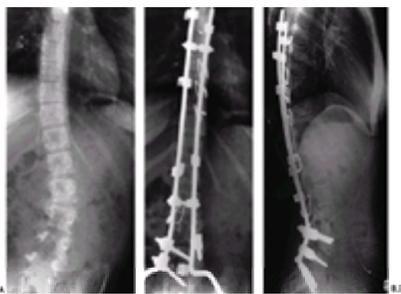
A 13-year-old girl has an L3-level paraplegia, but is not ambulatory. She is obese and has a progressive lumbar scoliosis and pelvic obliquity. A tethered spinal cord previously was released. A: Anteroposterior radiograph shows a 50-degree uncompensated lumbar scoliosis resulting in 35-degrees of pelvic obliquity. There is excessive lumbar lordosis. B: Postoperative anteroposterior radiograph shows complete correction of the scoliosis. The sacrum was included in the fusion because the lumbar scoliosis included the first sacral vertebra and the child was not ambulatory. Pedicle screws were used to secure the segmental instrumentation to L4 and L5. Anterior interbody fusion was performed from T10 to the sacrum. C: Postoperative radiograph shows restoration of normal sagittal alignment. Lumbar lordosis now measures 55 degrees. The patient has full extension of her hips, and is able to perform intermittent self-catheterization. (From ref. 59, with permission.)
